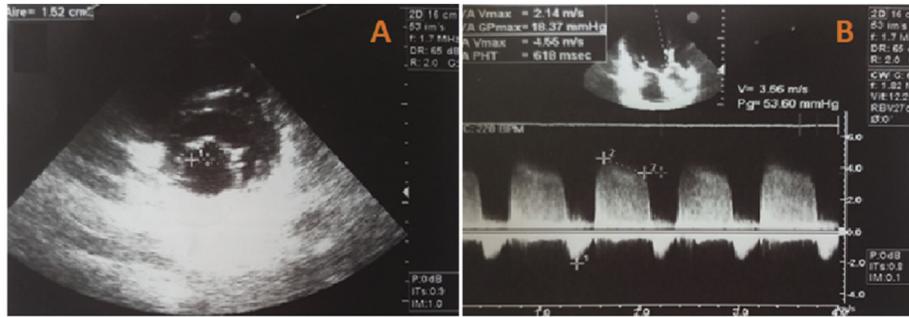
Transthoracic echocardiography of a 37-years-old woman with severe spondyloarthritis. (A) The parasternal short-axis view demonstrating a mitral stenosis (mitral valve areas $> 1.5 \text{ cm}^2$). (B) A four-chamber view revealing aortic regurgitation (peak gradient = 53.60 mmHg).
